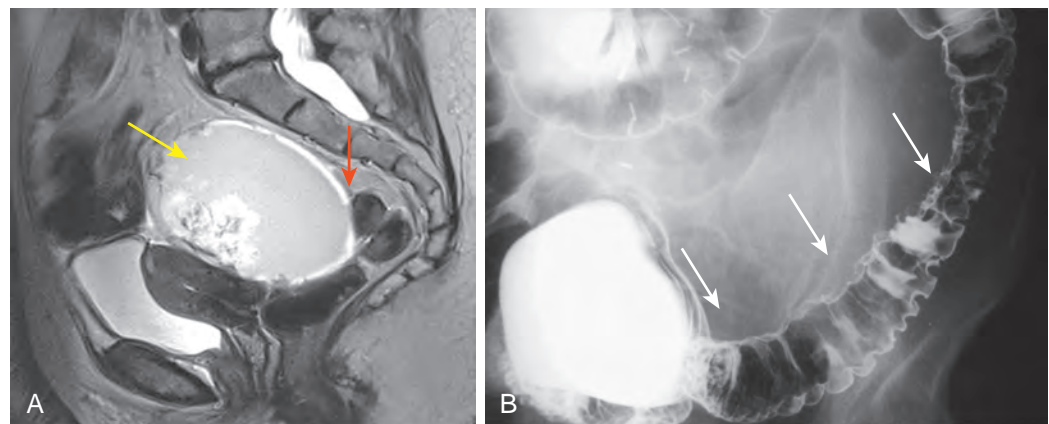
Ovarian carcinoma. A. Sagittal T2-weighted MRI scan shows a complex cystic mass (yellow arrow) compressing the anterior wall of the rectum (red arrow). B. In a different patient with ovarian carcinomatosis, multiple serosal implants (arrows) are identified along the medial aspect of the sigmoid colon.
